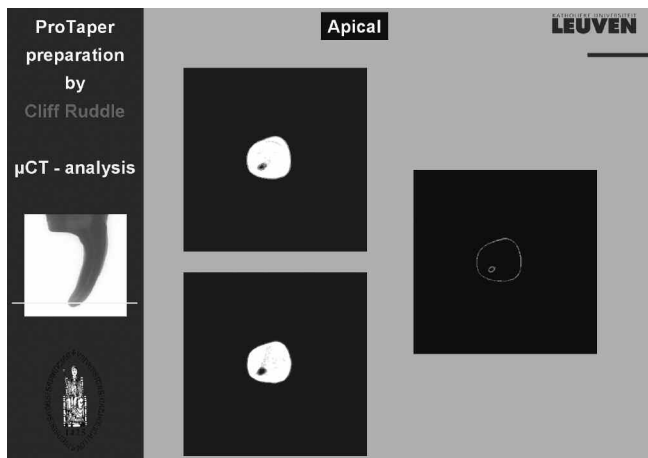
This figure shows horizontal μ CT sections through the “apical” one-third of the root. Note the ProTaper shape perfectly includes the original canal diameter.
